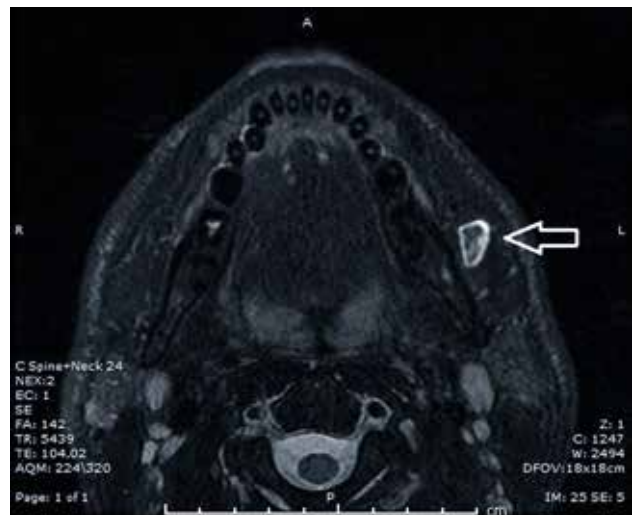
An axial non-contrast magnetic resonance imaging view of the mass.
